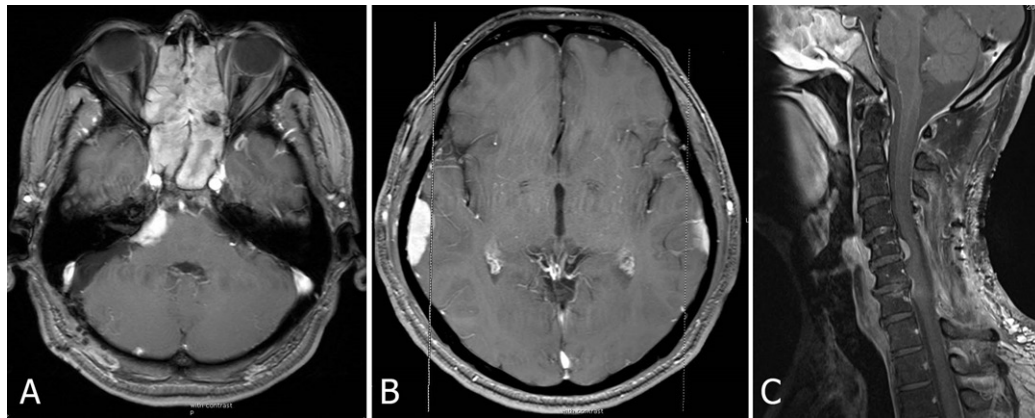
Preoperative T1 weighted gadolinium (Gd) enhanced MRI of case # 1. Axial MRI showing multiple nodules at right CPA (A), bilateral temporal area (B). Sagittal MRI (C) demonstrating multiple dural-based enhancing nodules at C5-7 with cord compression.
